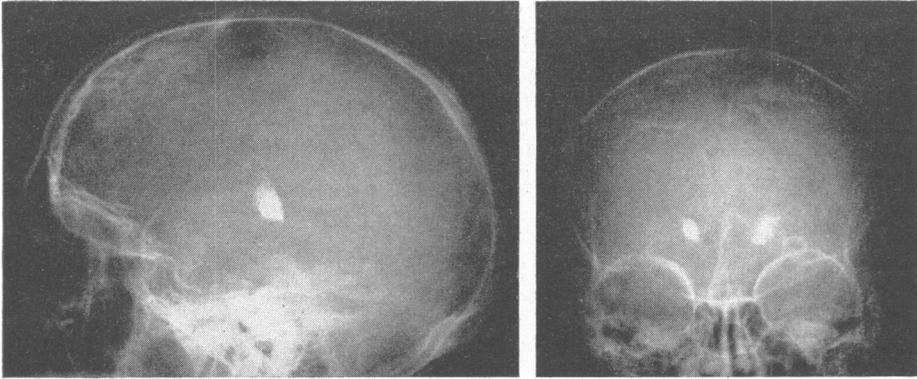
Roentgenographic appearance of bilateral thalamic lesions produced by alcohol-Pantopaque injections in Case V.
